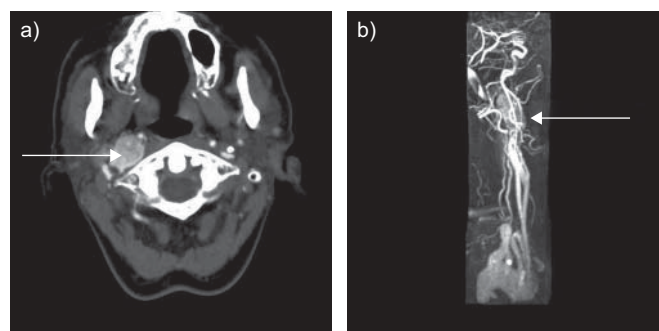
a) Contrast-enhanced computed tomography image of the neck showing a brightly enhancing mass (arrow) separating the internal carotid and internal jugular vein on the right side. b) Contrast-enhanced magnetic resonance angiography demonstrating multiple vessels within the mass (arrow) along the right carotid sheath extending from just above the carotid bifurcation to just below the skull base.
